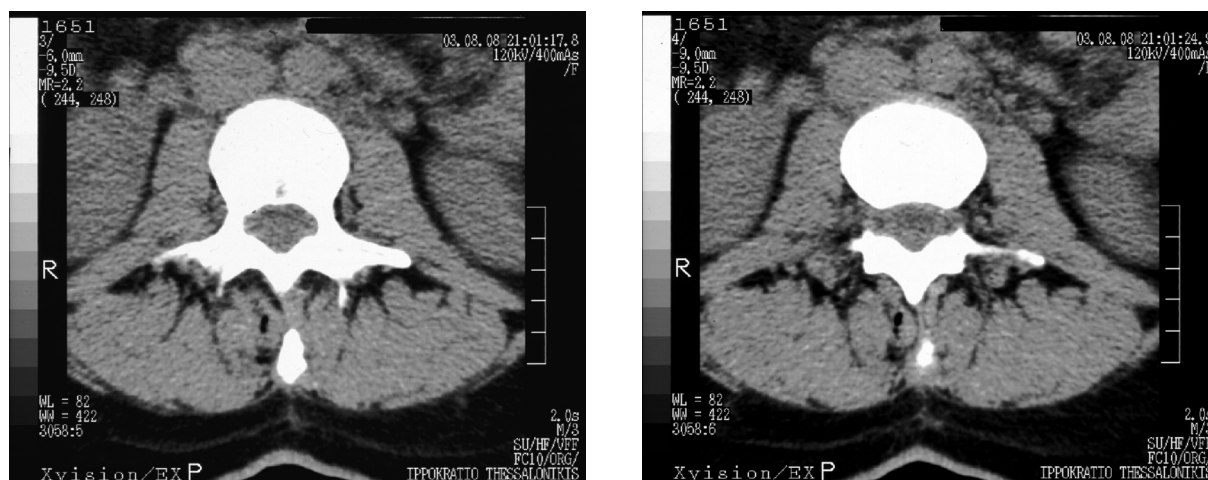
Tiny bubbles of air in CT examination picture suggesting the location of the epidural catheter.
